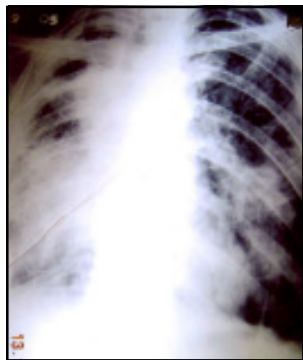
Chest radiograph (PA view) showing reticulo-nodular shadows on left and mass shadows on right, sparing apices.
